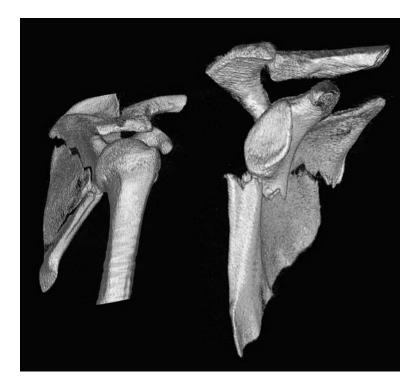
3D-CT image. Blunt force trauma to the left scapula. A compression fracture is present on the acromion process and a linear fracture extends across the scapular body (right side). The humerus was digitally removed in the image on the right to allow better visualization of the scapula and glenoid process. (Image reprinted with permission from Dr. Matthias Okoye and Dr. David Kiple.)
